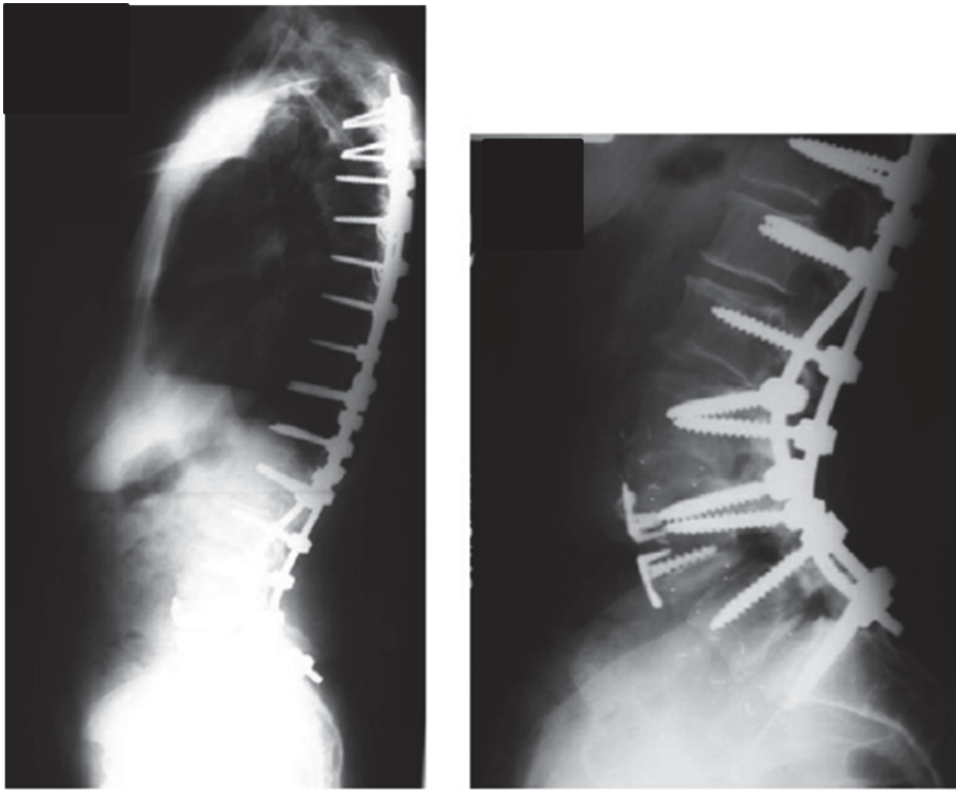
X-ray of a spine that has undergone an instrumentation + fusion procedure. Adapted from [90].
